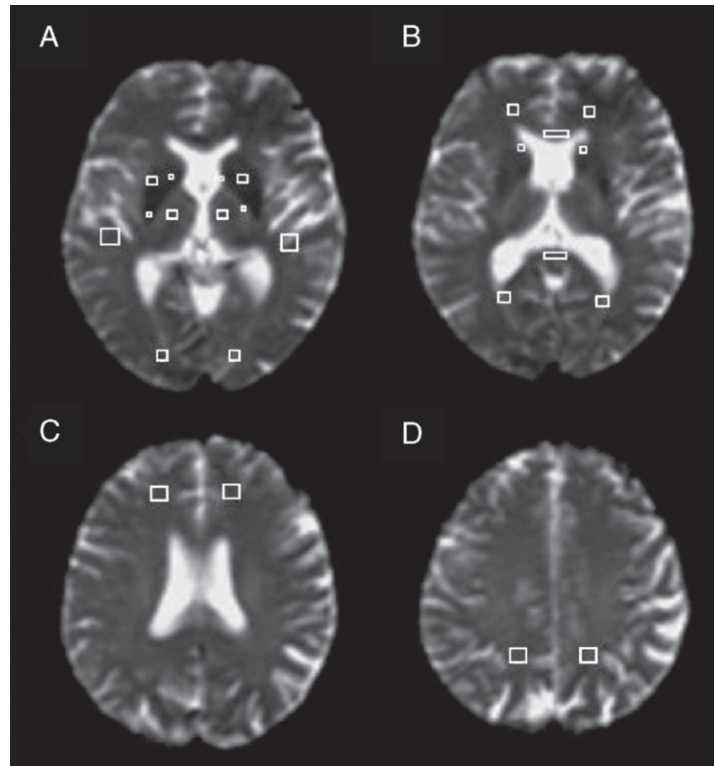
DT-MRI images of a patient with dementia with Lewy bodies. White squares represent regions of interest suspicious of small-vessel disease. (A) Internal capsule, putamen, thalamus, temporal and occipital lobes. (B) Genu and splenium of the corpus callosum, anterior and posterior pericallosal areas, caudate nucleus. (C) Frontal lobes. (D) Parietal lobes. Abbreviation: DT-MRI, diffusion tensor magnetic resonance imaging. Reproduced with permission from Bozzali and Cherubini.⁷⁶
